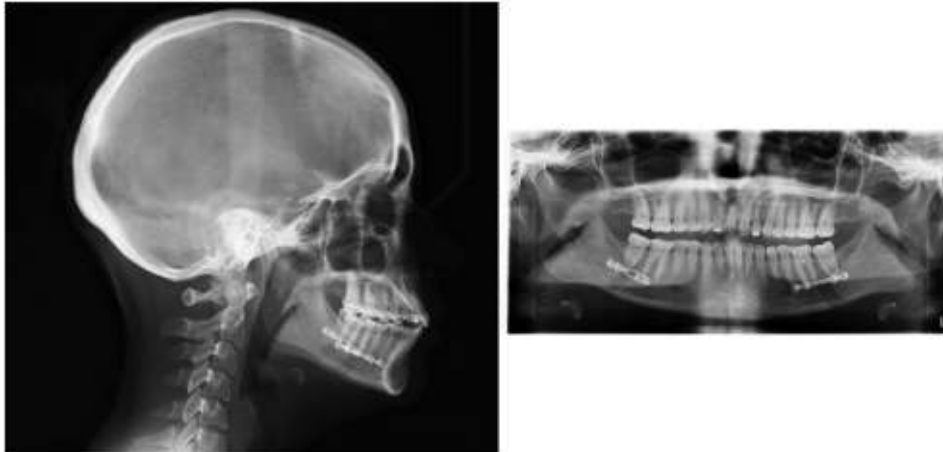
Post-treatment lateral cephalograph and orthopantomograph showing fulfillment of treatment objectives.
